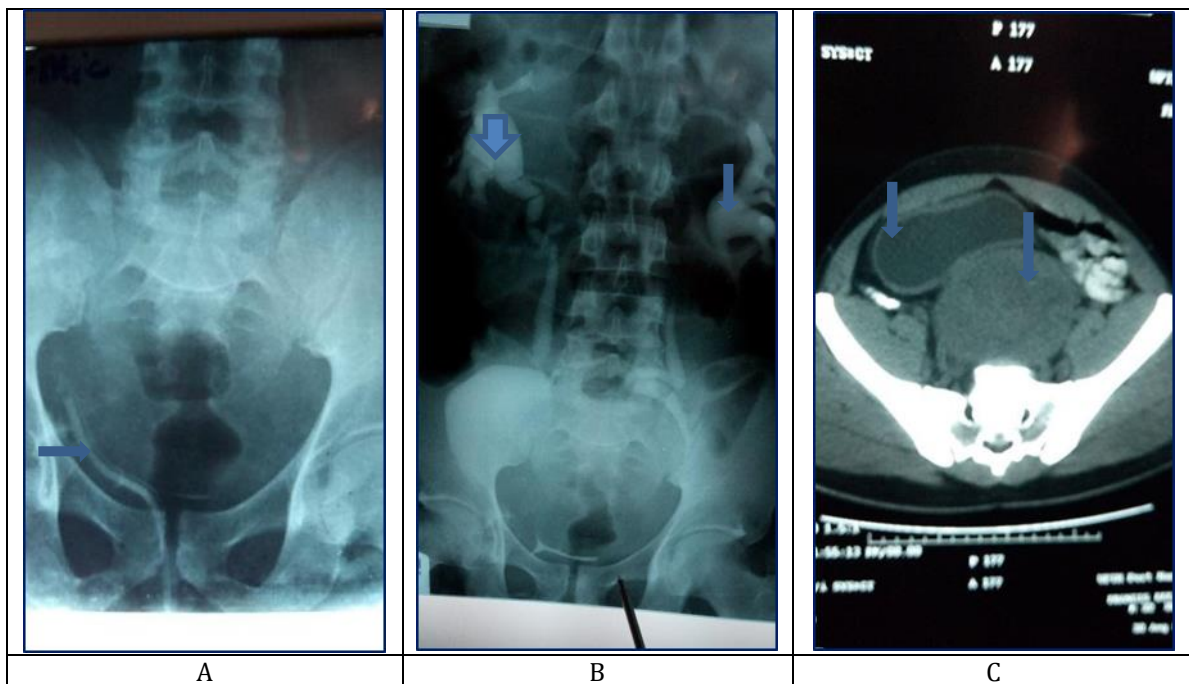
A and B are intravenous urographs of Patient 3.1, C is a transverse pelvic CT scan graph of the same patient: A, This shows the post micturition phase of intravenous urography (IVU). The contrast-opacified urethral catheter (marked with the arrow) is deviated to the right. B, bilateral hydronephrosis resulting from the huge pelvic mass (distended renal pelvis arrowed on each side); C, Contrast-opacified CT scan graph of the pelvis showing a pelvic mass that typically resembles a prostate mass. Urine-filled urinary bladder is compressed by the mass and displaced to the right of the patient (arrow)
